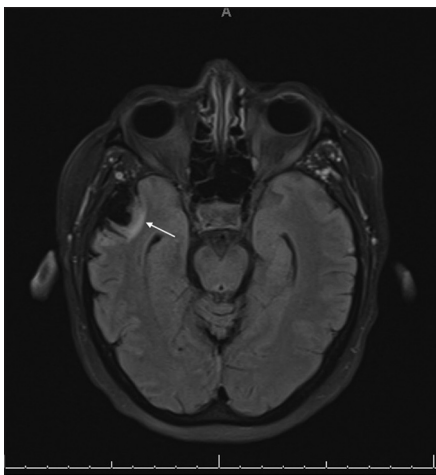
Magnetic resonance imaging (T2 flare) showing encephalomalacia of the right anterior temporal lobe and right frontal lobe
